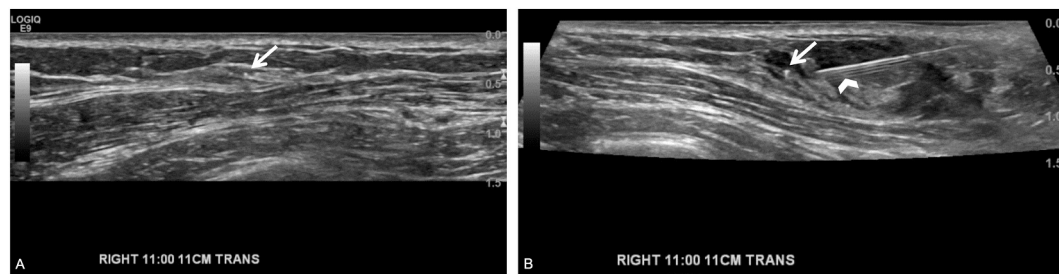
Hydrodissection to aid with biopsy clip visualization. (A) A 54-year-old woman status post neoadjuvant chemotherapy presents for preoperative localization of the previously placed clip, but the echogenic biopsy clip (arrow) is questionably identified on the pre-localization ultrasound. (B) Fluid instilled with the hydrodissection needle (chevron) surrounds the echogenic clip (arrow), which is more confidently visualized with the posterior reverberation artifact. Video 5 shows the clip being surrounded by fluid and the application of gentle tapping on the biopsy clip by the hydrodissection needle for added confirmation of the target.
